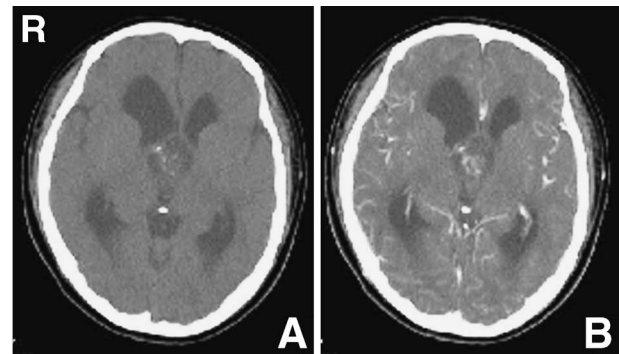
Computed tomography scans showing the mass as mixed signal with fine calcification in the third ventricle (left) and slightly enhanced after administration of contrast medium (right).
